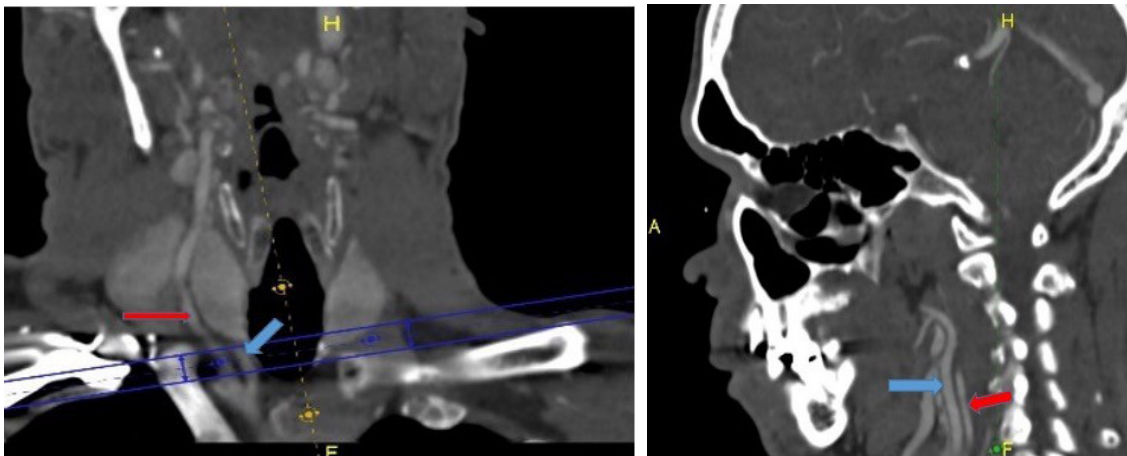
3-D CTA reconstructions reveal the unique origins and routes of the right internal (red arrows) and external (blue arrows) carotid arteries.
